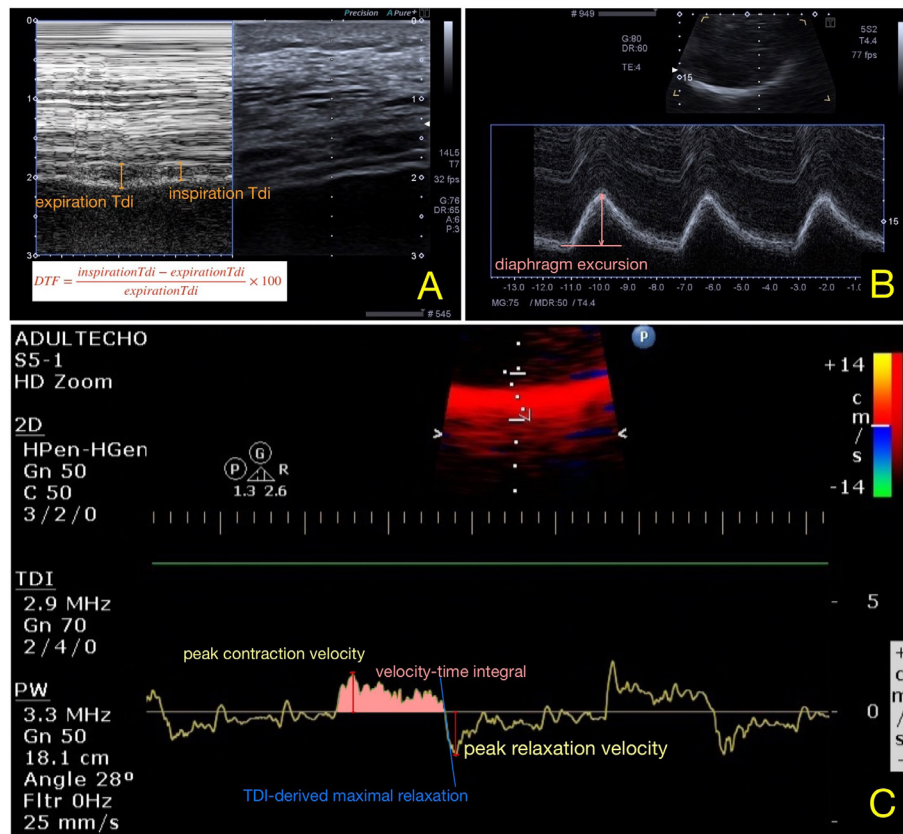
Diaphragm ultrasound.
